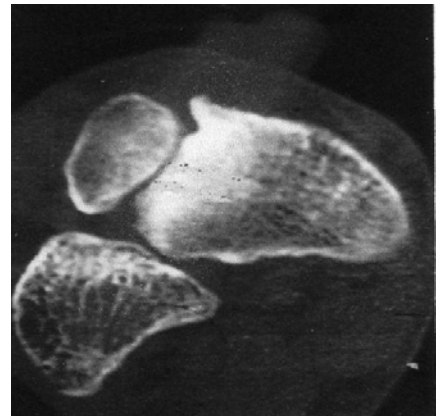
A particular of CT of left foot showed a bipartition of tarsal scaphoid.
